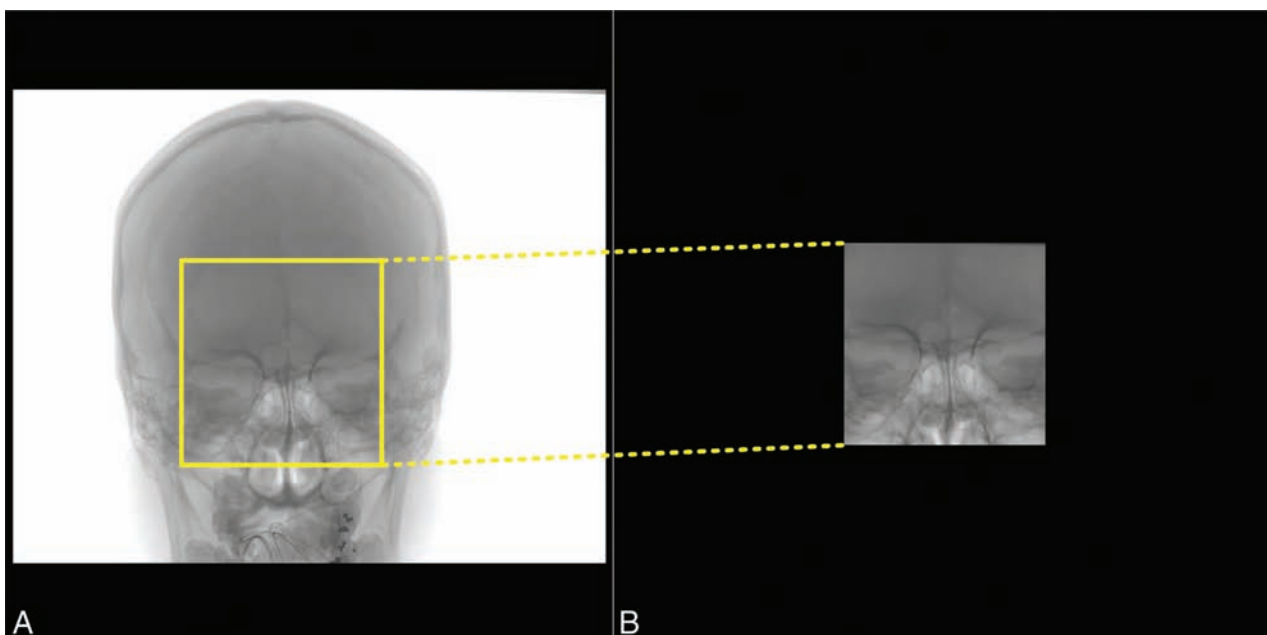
Sample projection image from noncollimated full-head C-arm CT acquisition (A) and VOI C-arm CT acquisition (B) with the x-ray source collimated in both horizontal and vertical directions.
